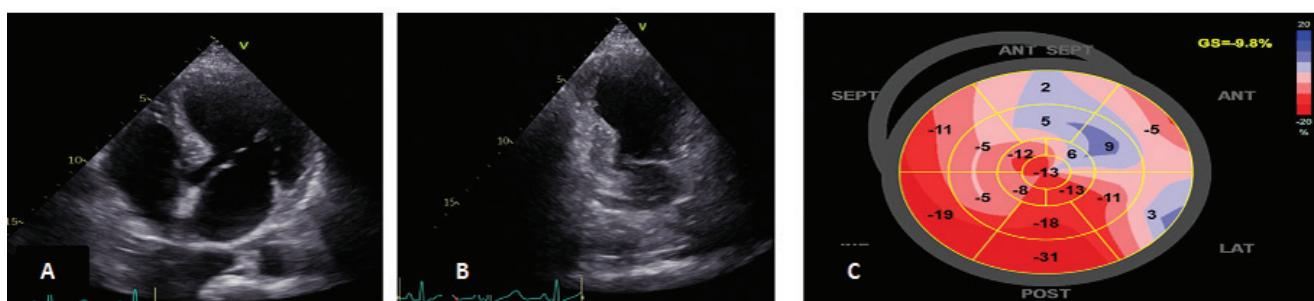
(A, B). Echocardiography during the hospitalization with apical and apico-septal akinesia, left ventricular ejection fraction 45%. (C). Reduced global longitudinal strain -9.8%.
